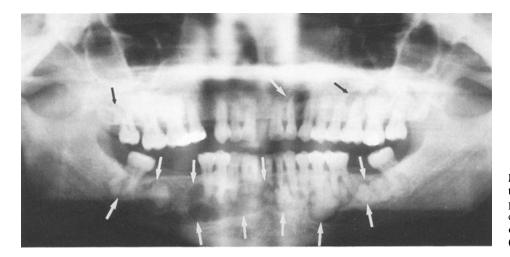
Orthopantomograph of the proband showing multiple periapical radiolucent areas with central radiodense regions typical of periapical cemental dysplasia (arrows)
